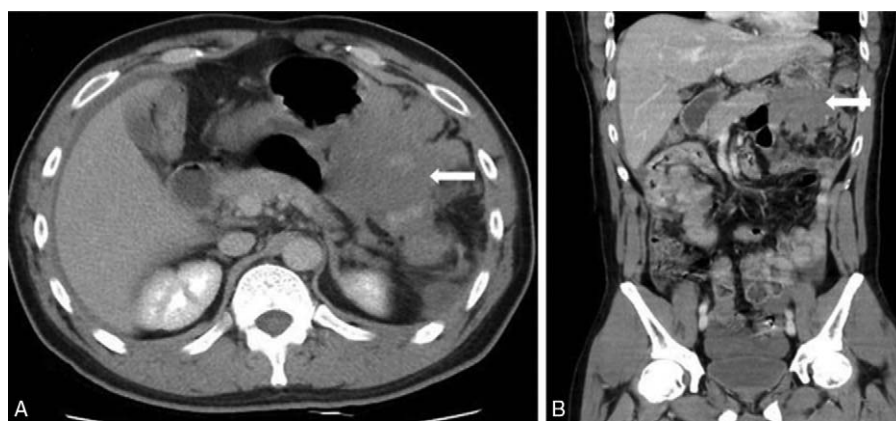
(A) Transverse view and (B) axial view of abdominal computed tomography with enhancement showed a large lobular-contour homogenous slightly hyperdense lesion without enhancement along the greater curvature of stomach in the lesser sac.
